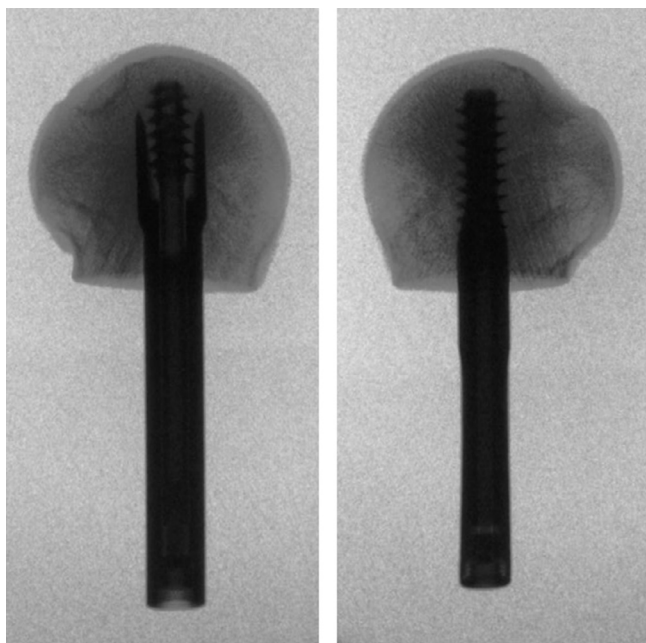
Anteroposterior X-rays of centrally inserted RoSA-HE (left) and Gamma-RC (right).
